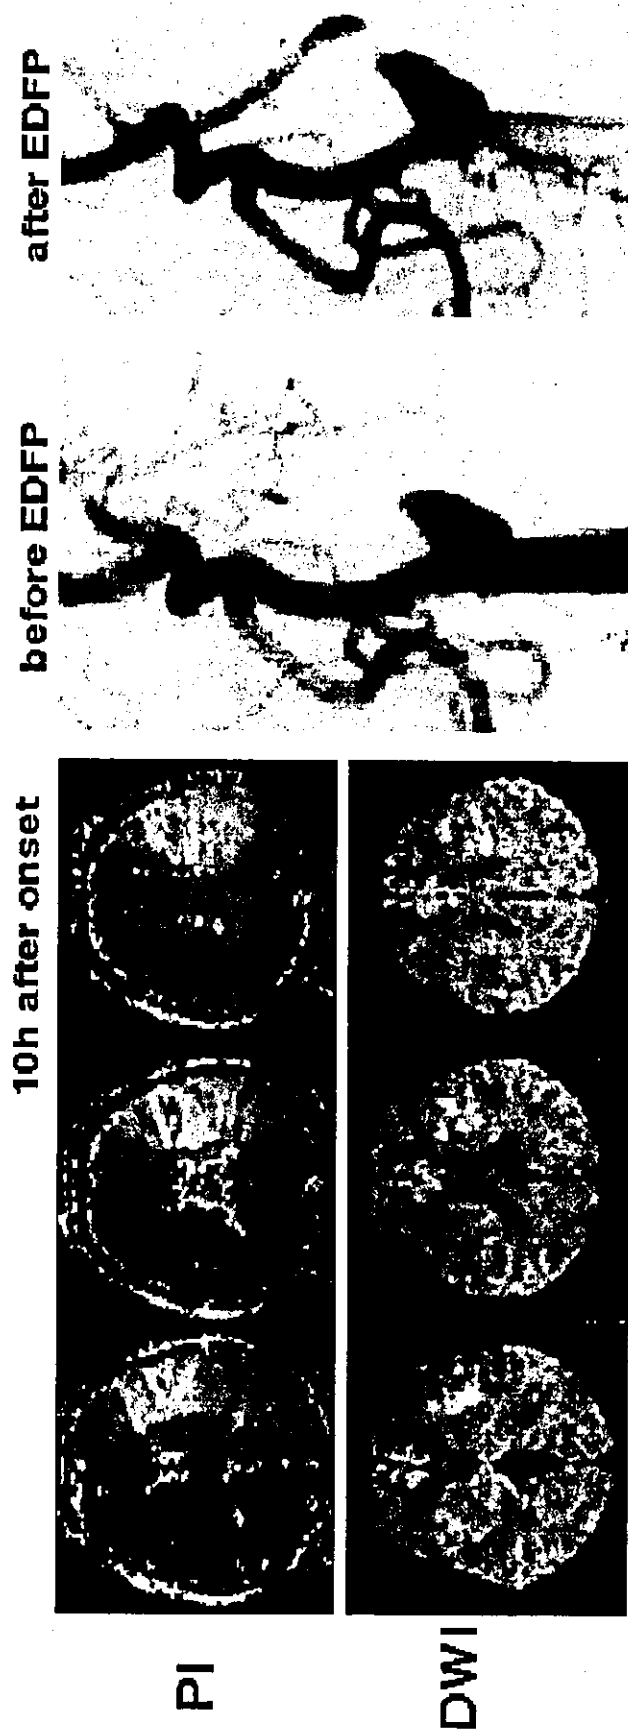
MRI images and cerebral angiograms in Patient 1. PI, perfusion image (time-to-peak image); DWI, diffusion-weighted image.
